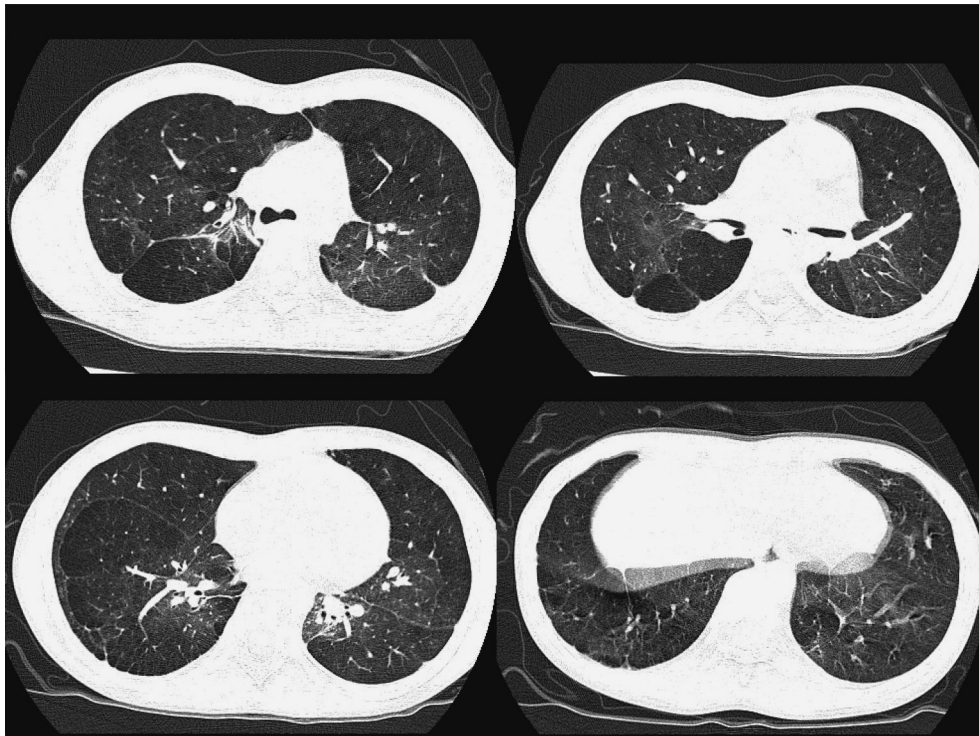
High-resolution chest computed tomography scan.
